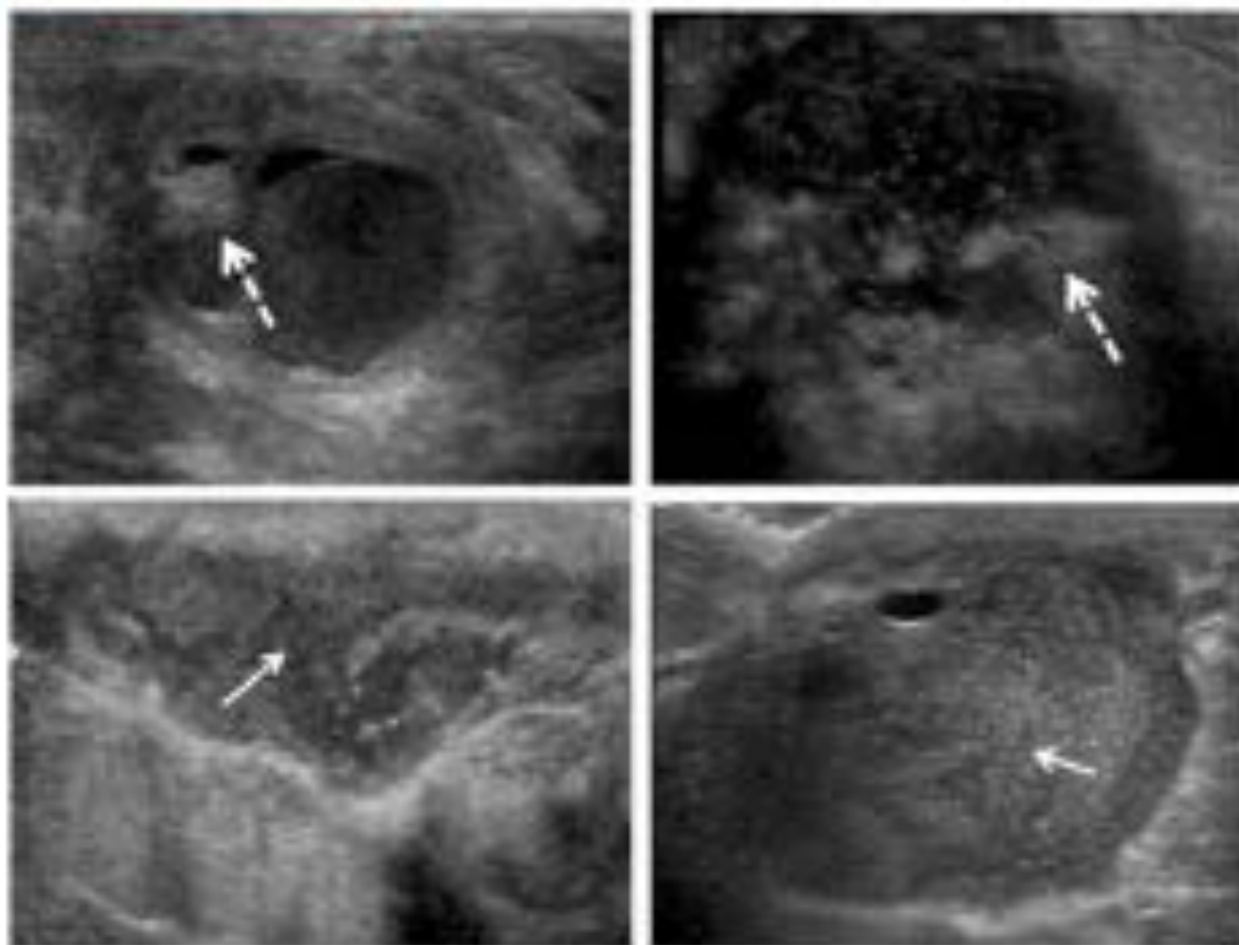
Variability of abscess contents by ultrasound imaging. These images of 4 different abscesses demonstrate lumpy/nodular demonstrated with a dash arrow and smooth debris with a solid arrow
